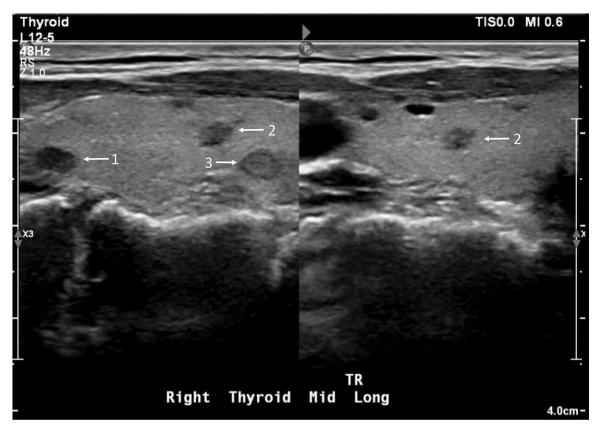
Thyroid nodules identified by screening thyroid ultrasound in a *RET* K666N carrier. Sagittal (left) and transverse (right) views of thyroid nodules in the right thyroid lobe. Thyroid ultrasound imaging in the 60-year-old father, a *RET* K666N carrier, showed multiple solid, hypoechoic thyroid nodules that underwent fine-needle aspirate biopsy. Nodule 2 was positive for medullary thyroid carcinoma.
